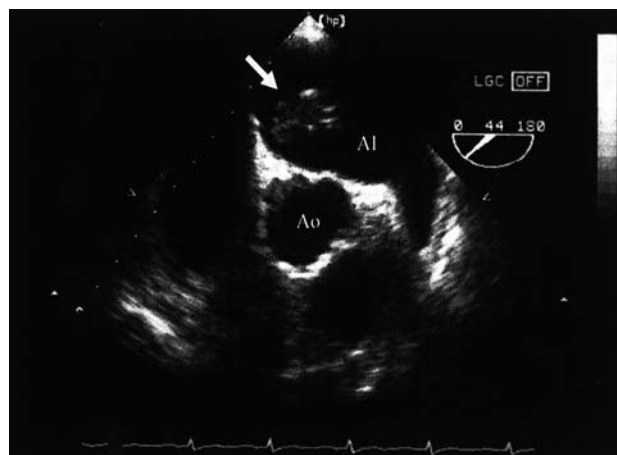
Transesophageal echocardiogram. A small tumor (arrow) is present with its pedicle implanted in the mid-interatrial septum. LV indicates left ventricle; AO, aorta.
